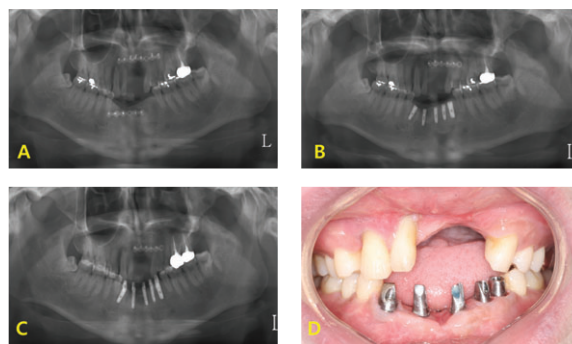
A) Panoramic radiograph of block bone graft
